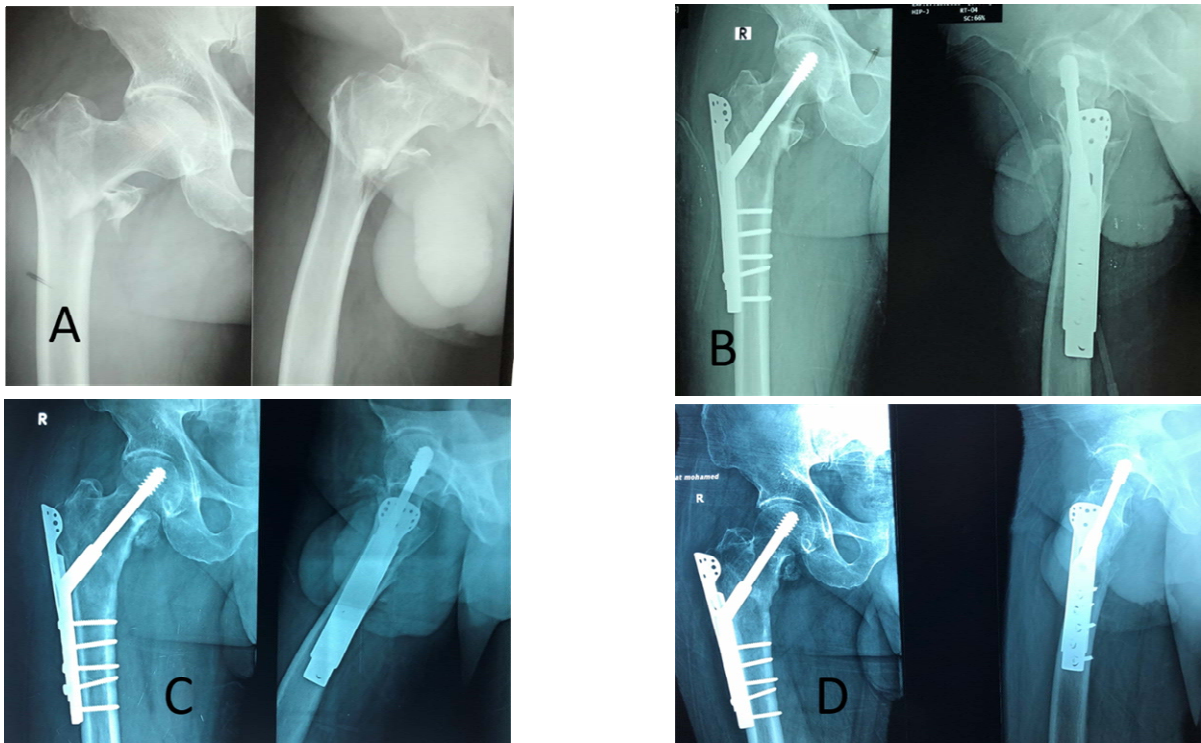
60 years male patient presented with per trochanteric fracture (31A2-2) of the right femur after falling to the ground, treated with DHS and TSP after 7 days from admission. Full weight-bearing was allowed after 16 weeks. After 18 months, HSS was 100. A] Preoperative x-rays. B] Immediate postoperative X-rays. C] 3 month follow up x-ray. D] 6 month follow up x-ray
